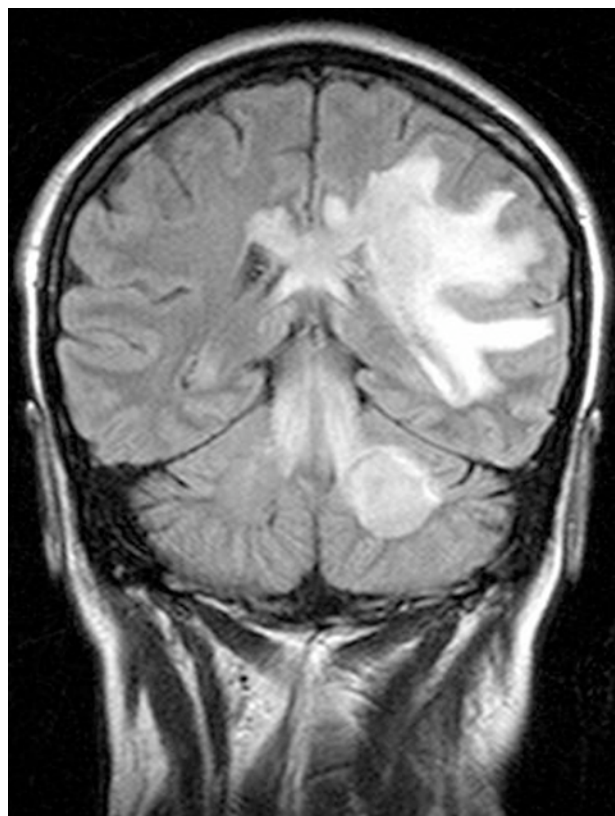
Cerebral MRI (FLAIR).
